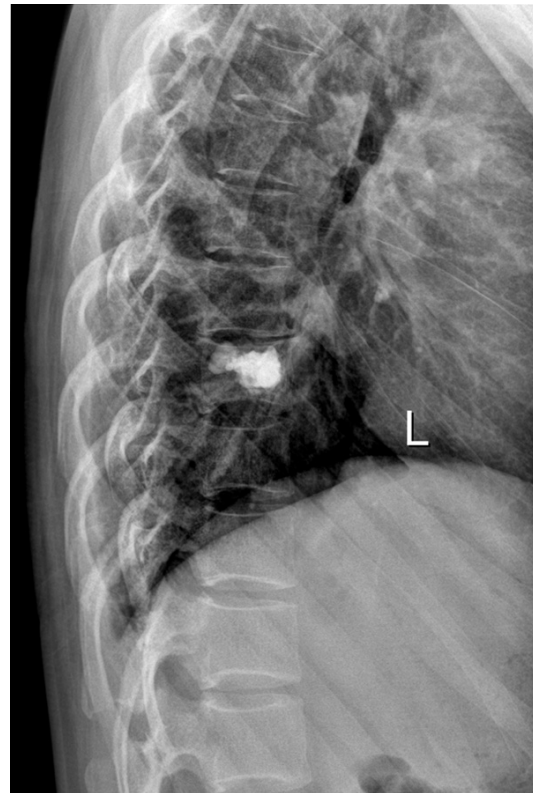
Radiography after 1 week of the surgery showed the recovery of height of T8.
